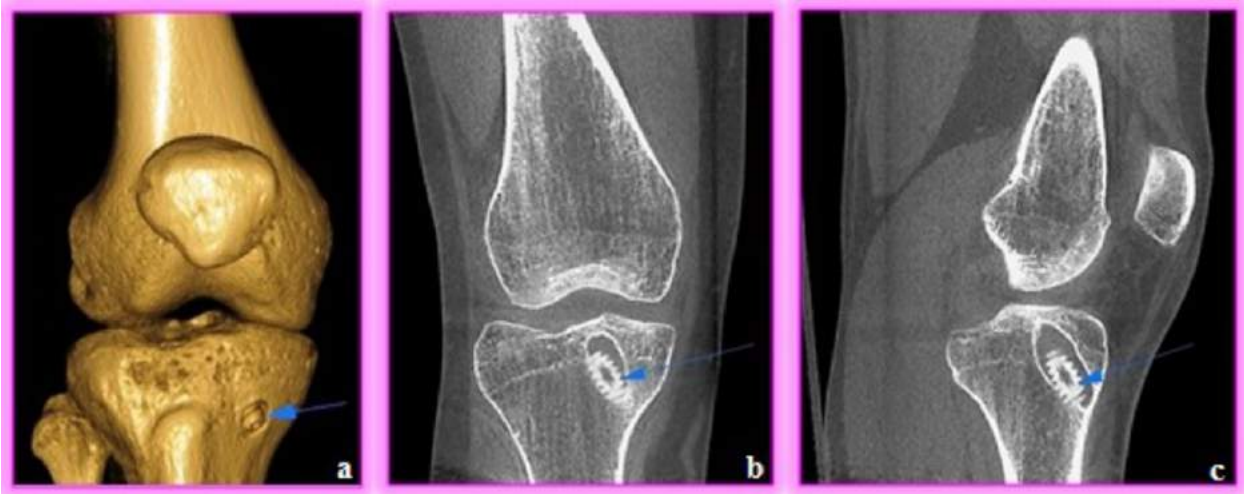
the CBCT-images (axial - a, coronal - b and sagittal - c) of the right knee joint with the detailed mapping of the bone structure
